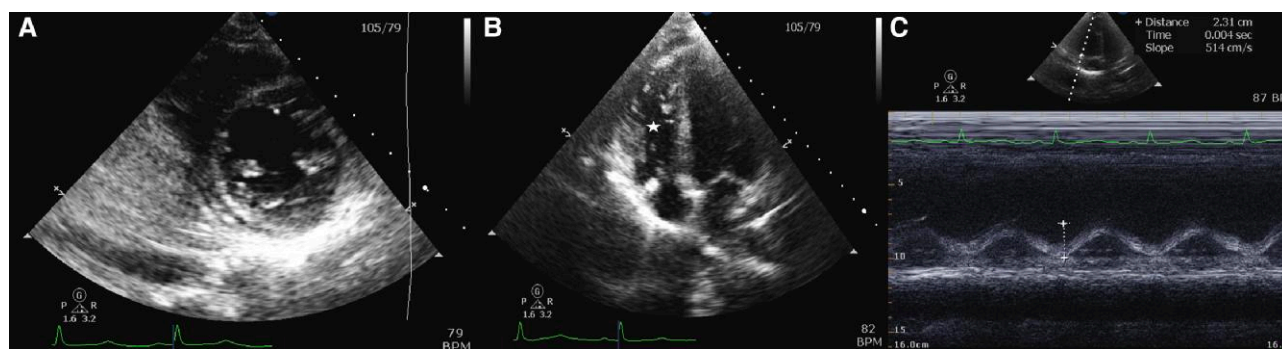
Transthoracic echocardiogram (TTE) 4 months prior to admission: (A) Parasternal short axis view showing normal ventricles and papillae. (B) Apical four chamber view with normal size right ventricular (star). (C) Normal tricuspid annulus planar systolic excursion (TAPSE) of 2.3 cm. TTE, transthoracic echocardiogram; TAPSE, tricuspid annulus planar systolic excursion.
